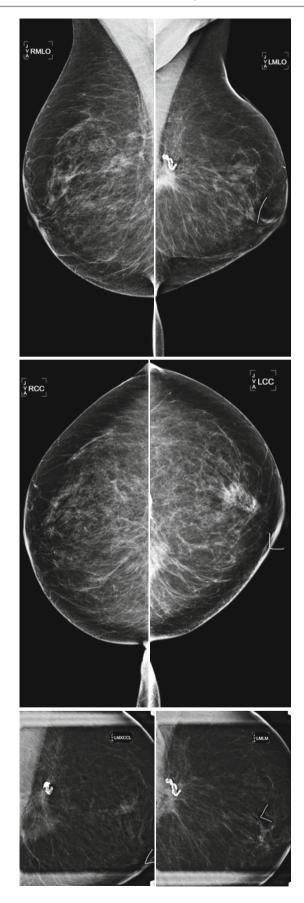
(a) A 60-year-old female with prepectoral silicone implants and new palpable abnormality in the medial left breast. Mammography demonstrates a focal bulge in the medial aspect of the left implant. High-density material is visualized within the breast parenchyma along the inferior aspect of the left implant. (b) Silicone-sensitive MRI sequences demonstrate both intracapsular and extracapsular implant rupture. A focal bulge of the implant is visualized in the medial left breast corresponding to the palpable complaint. Extracapsular silicone is also visualized anterior to the implant on the sagittal view. (c) Axial T2 images demonstrate intracapsular upture bilaterally. (d) The patient subsequently elected for implant explantation with postsurgical changes in the posterior central breast. Note coarse capsular calcifications and nodular silicone granulomas
